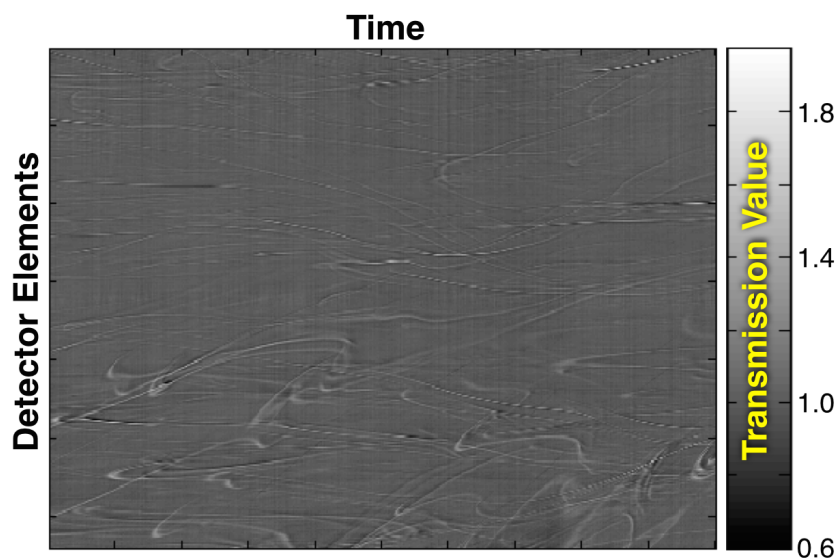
Examples of schlieren errors in optical CT. Here, the flow-like errors caused by imperfect dissolution of matching agents in the matching bath are shown in a transmission scan of a recently mixed bath.
